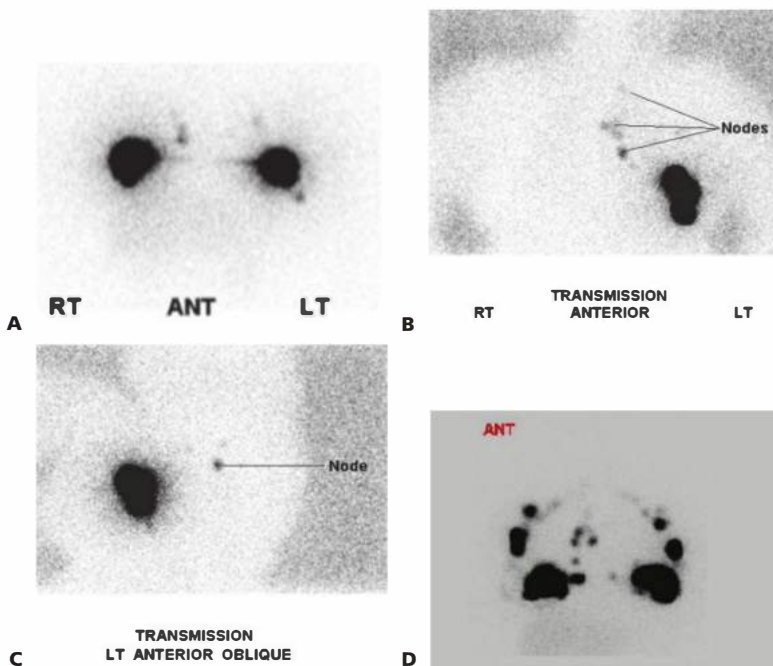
• A. Lymphoscintigraphy of bilateral breasts demonstrating internal mammary nodal drainage on the right in the anterior projection. B. Anterior projection of lymphoscintigraphy showing radioactive uptake in two interspaces with faint uptake base of neck. In this view, the axillary node is faint. C. Left anterior oblique projection shows the axillary uptake more intensely. D. Lymphoscintigraphy (anterior projections) with lymphatic drainage to multiple internal mammary nodes.
